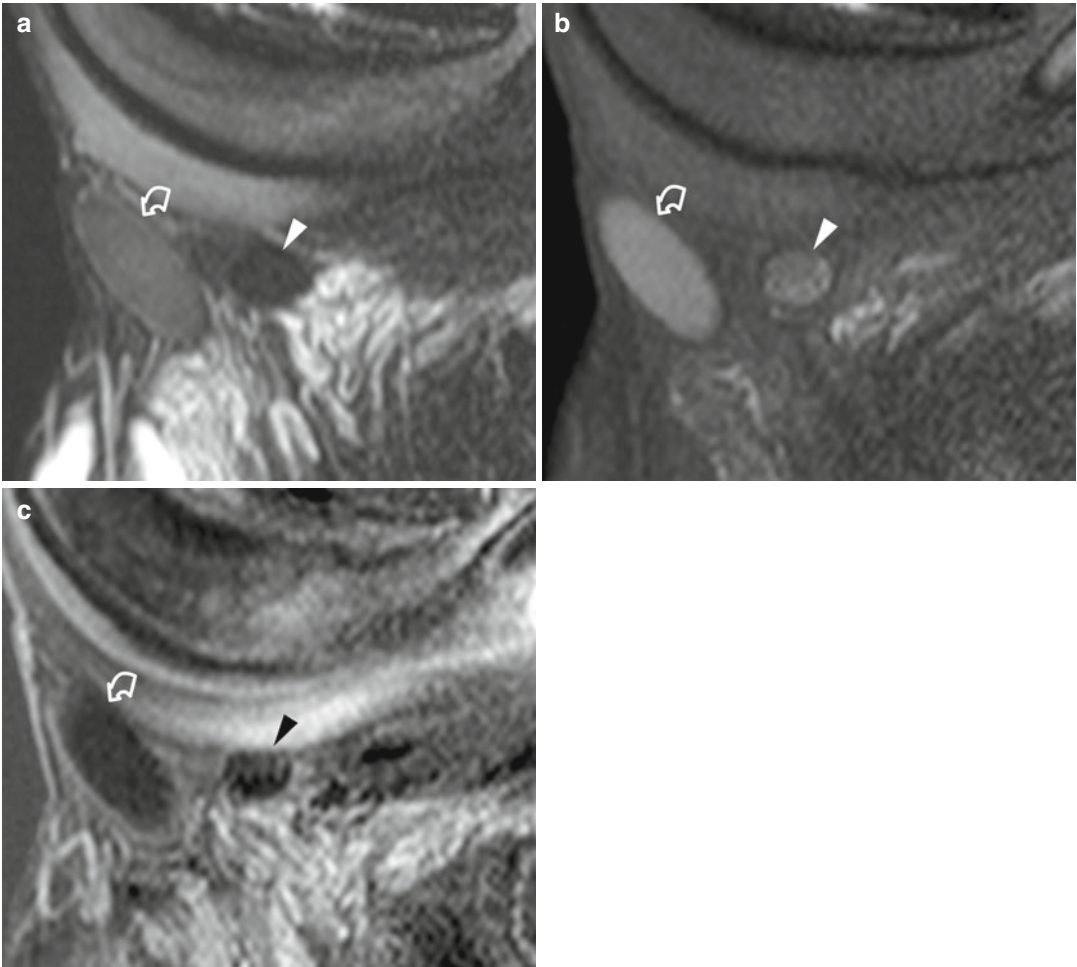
Epidermoid cysts of the scrotal wall. T2-weighted (a) and T1-weighted sagittal images with fat suppression (b) show two well-demarcated masses, the larger with intermediate signal intensity on T2-weighted images (*curved arrow*) and the smaller with low signal intensity (*arrowhead*). Both
